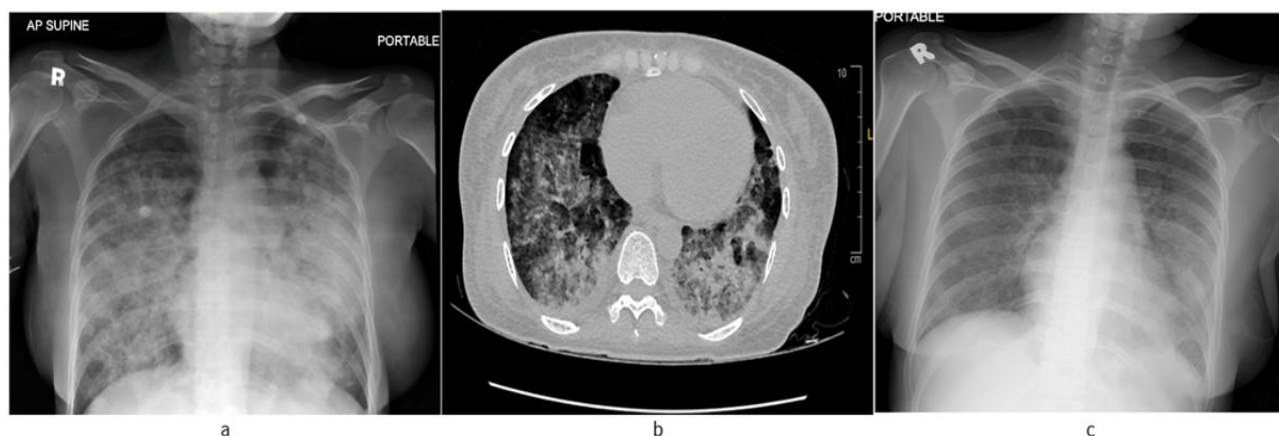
(a) Antero-posterior view of the chest X-ray showing diffuse nodular opacities suggestive of pulmonary hemorrhage; (b) Axial computed tomography of the chest showing “crazy paving” of bilateral lower zones, in line with pulmonary hemorrhage; & (c) Antero-posterior view of the chest x-ray showing resolution of pulmonary hemorrhage after completion of the first cycle of induction (Reprinted with permission of the patient)
